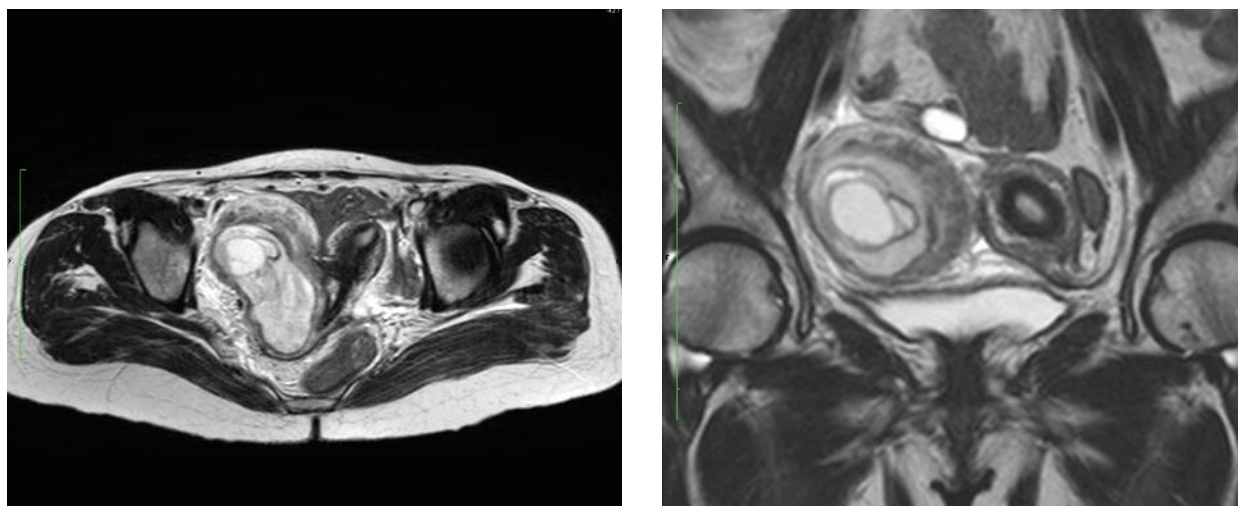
2B: MRI findings: Suggest possibility of perforation at right lateral wall of cervix with large collection/hematoma in right adnexa
